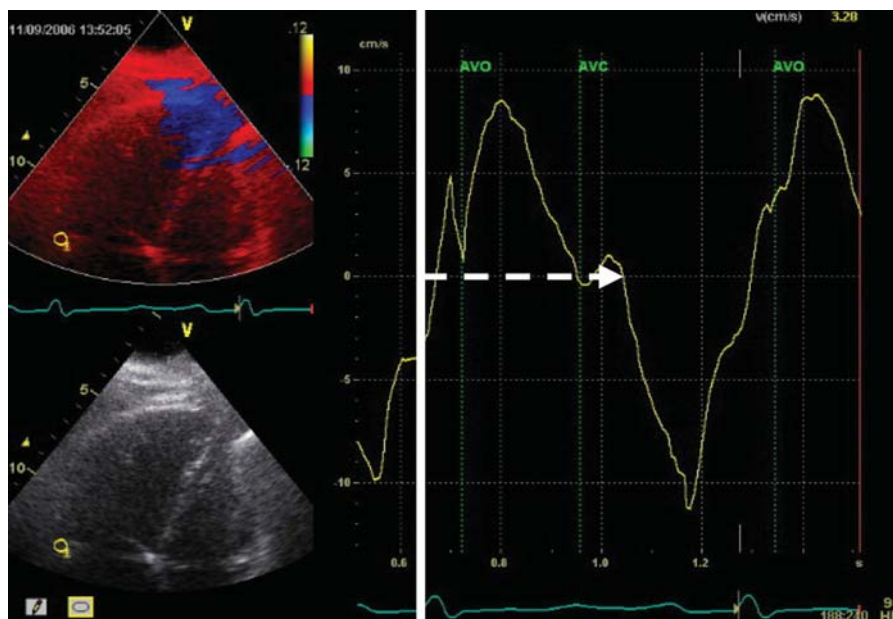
Measurement of right ventricular (RV) contraction duration. Right ventricular contraction duration using tissue Doppler imaging is measured as the time interval between onset of QRS and onset of RV early diastolic relaxation. Dotted arrow represents RV contraction duration.
